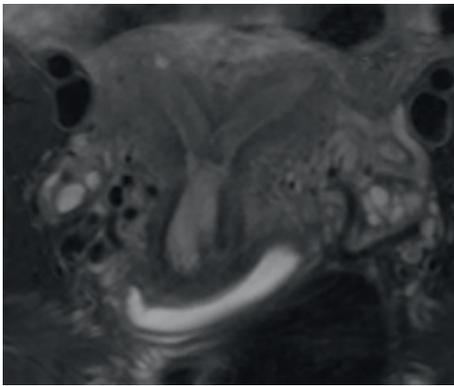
Magnetic resonance imaging of uterine septum.
